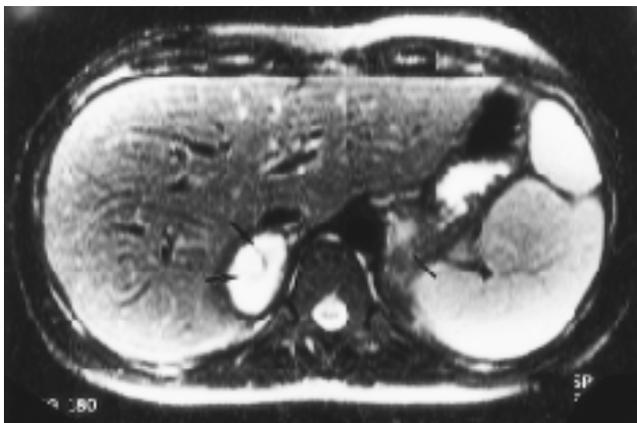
Follow-up MR imaging 20 days later. T2-weighted MR image shows slight decrease in size of both adrenal glands and more intense size of high signal intensity (arrows), more pronounced on the right side.
